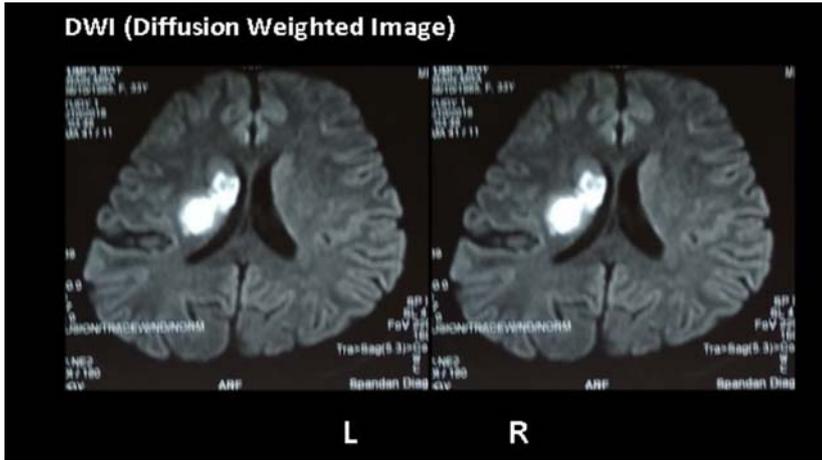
A Diffusion Weighted Magnetic resonance image of a 33 year old woman with a right putaminal infarct extending to the right periventricular region. L=left hemisphere; R= right hemisphere
